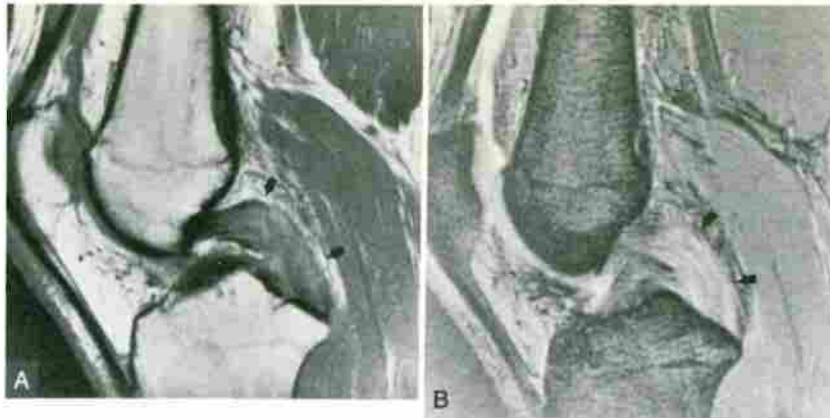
Acute complete posterior cruciate ligament (PCL) rupture. A, Sagittal T1-weighted (TR/TE, 800/20) image through PCL demonstrates interruption of the fibers and replacement by a mass of edema and hemorrhage (arrows). B, Corresponding sagittal gradient-echo (TR/TE, 550/20; angle, 30 degrees) image.
